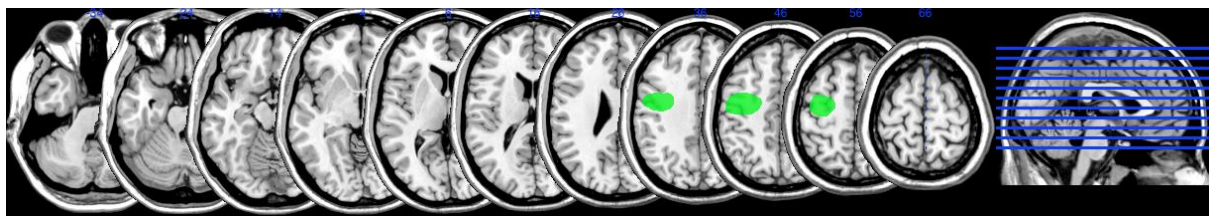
MRI scan of patient DP
